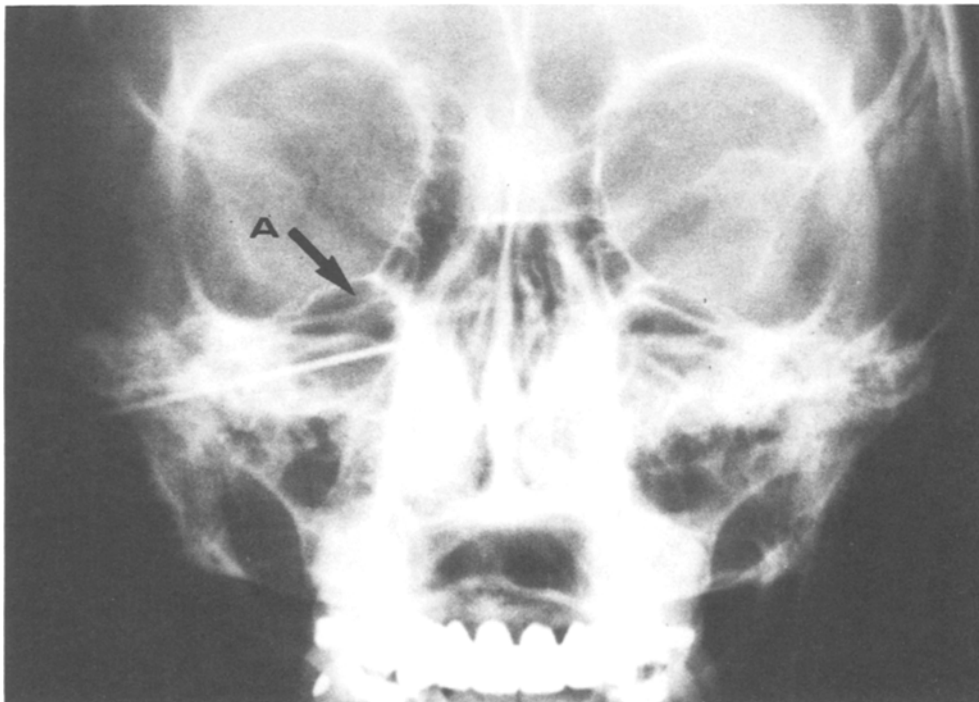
Roentgenogram of the skull, anteroposterior projection. The tip of the needle-electrode lies immediately under the foramen rotundum (A)
